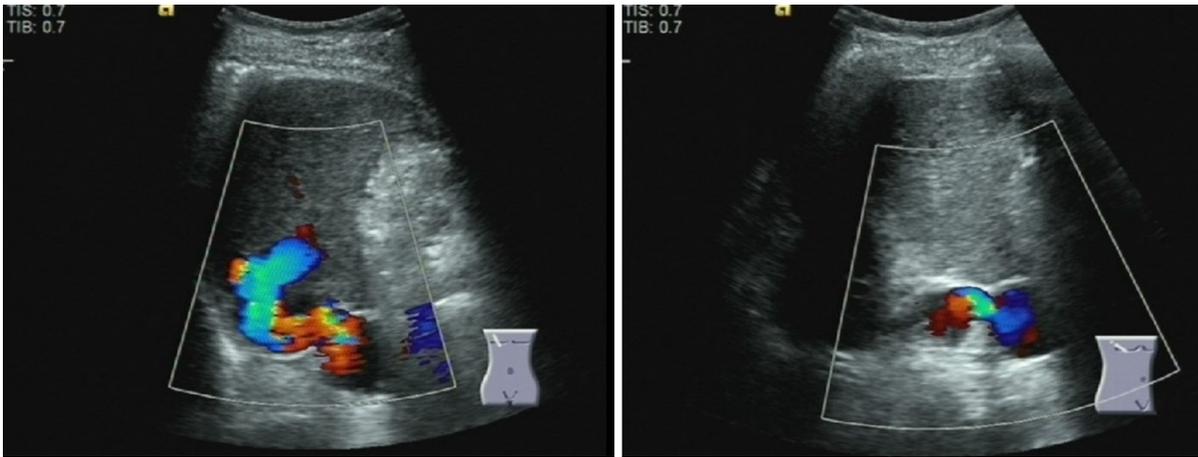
Color Doppler ultrasound showing the existence of intrahepatic portosystemic shunt.
